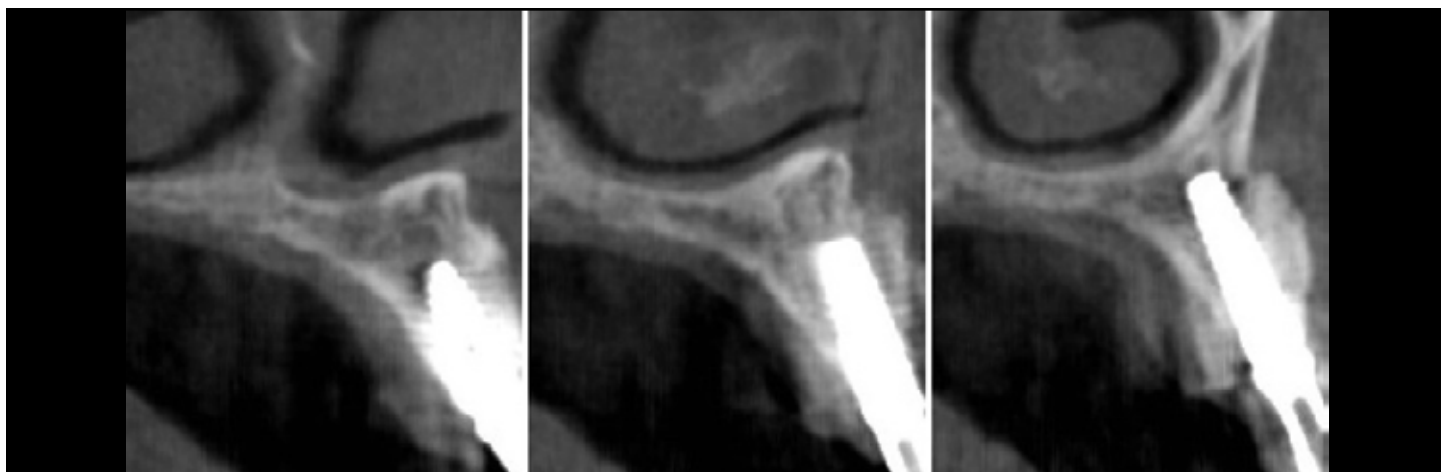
The cross sectional image of CBCT reveals stable bone augmentation over the exposed implant surface after 1 year loading.
